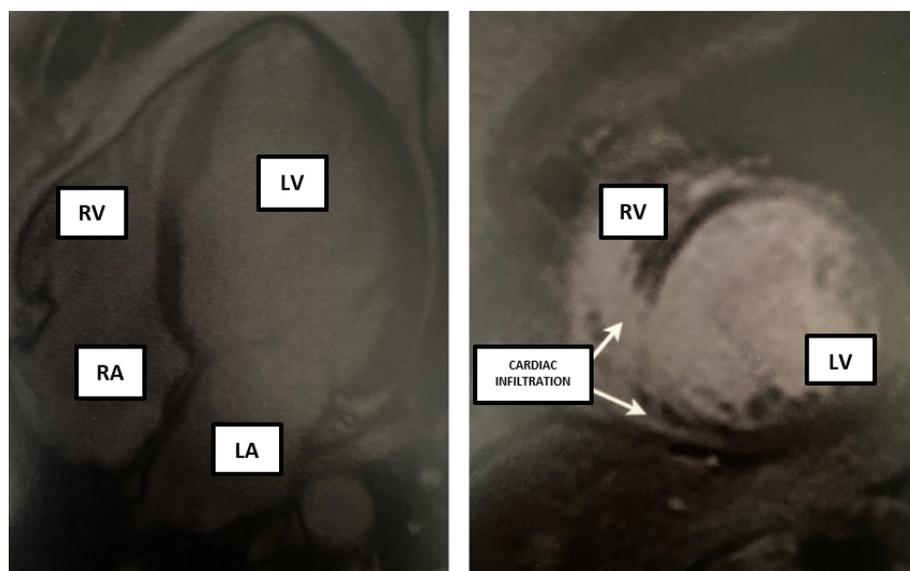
Cardiac magnetic resonance imaging. CMRI: moderate heterogeneous late enhancement of inferior, septal and basal mesocardium segments. RV: right ventricle; LV: Left ventricle; RA: right atrium; LA: Left atrium.
